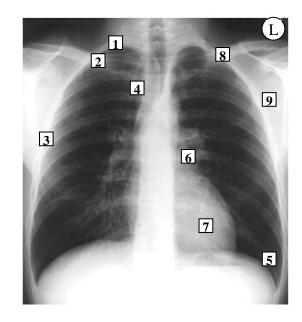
Radiography of a human and the places where different trauma in the thoracic zone can be seen [5].
